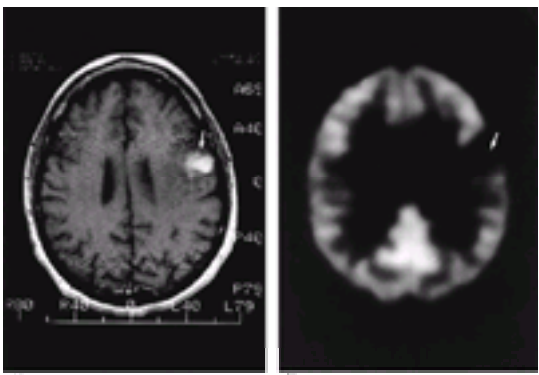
(a) Anatomic study showing enhancement in the left frontal area (arrow)—recurrence or necrosis?(b) FDG-PET image at the same level showing a hypometabolic area (arrow) consistent with radiation necrosis.
